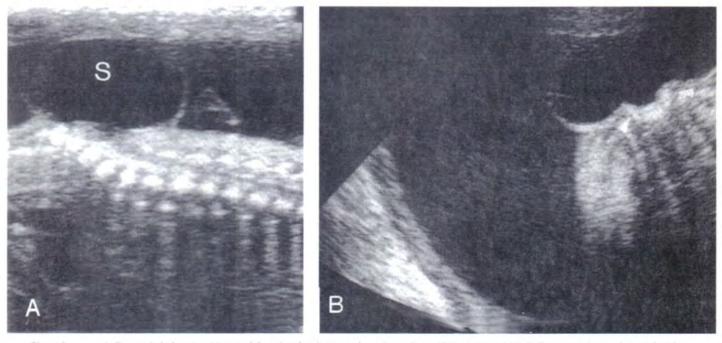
A. Parasagital ultrasound image of the spine showing a myelomeningocele sac (S) beginning at L5. B. Transverse image shows splayed posterior elements (arrows).
